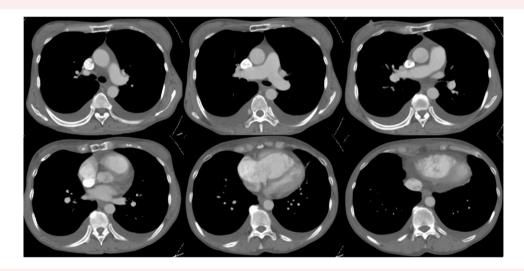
Contrast-enhanced computed tomography on the day of admission. There is no evidence of thrombi in pulmonary arteries.
